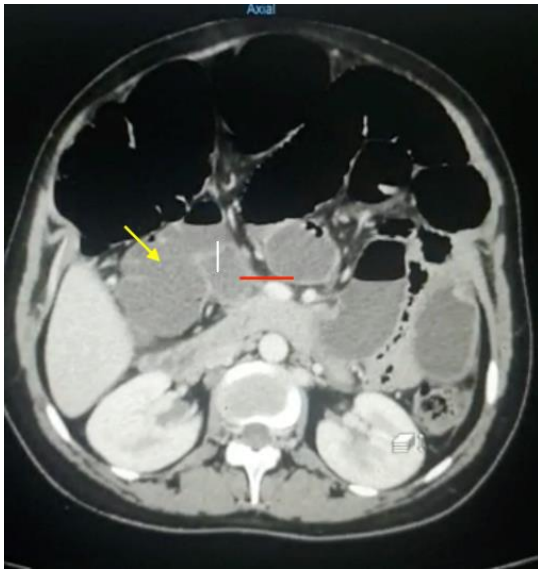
CT scan image of cecum bascule (yellow arrow: caecum, red arrow: last loop of intestine)
